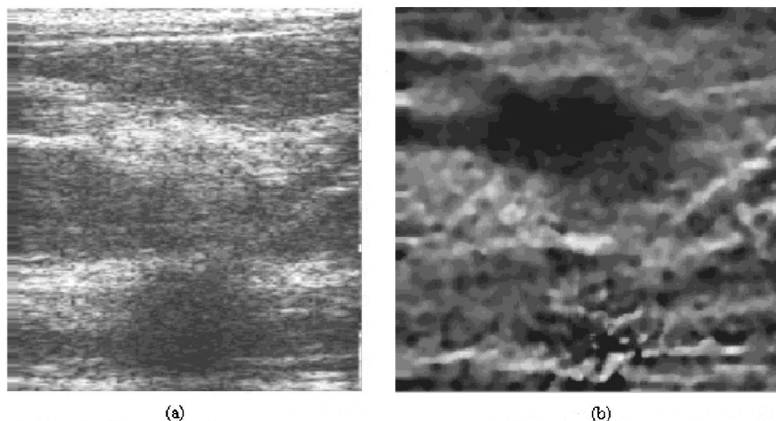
(a) Sonogram and (b) elastogram of an invasive ductal carcinoma *in vivo* at 5 MHz. Note the irregular mass seen on the elastogram where only an echogenic band and shadow are seen on the sonogram. The lesion is clearly visible as a dark (hard) area on the elastogram, and elastographic structures are visible in the distal sonographic shadows. The elastographic scan size is approximately $40 \times 40 \text{ mm}^2$
